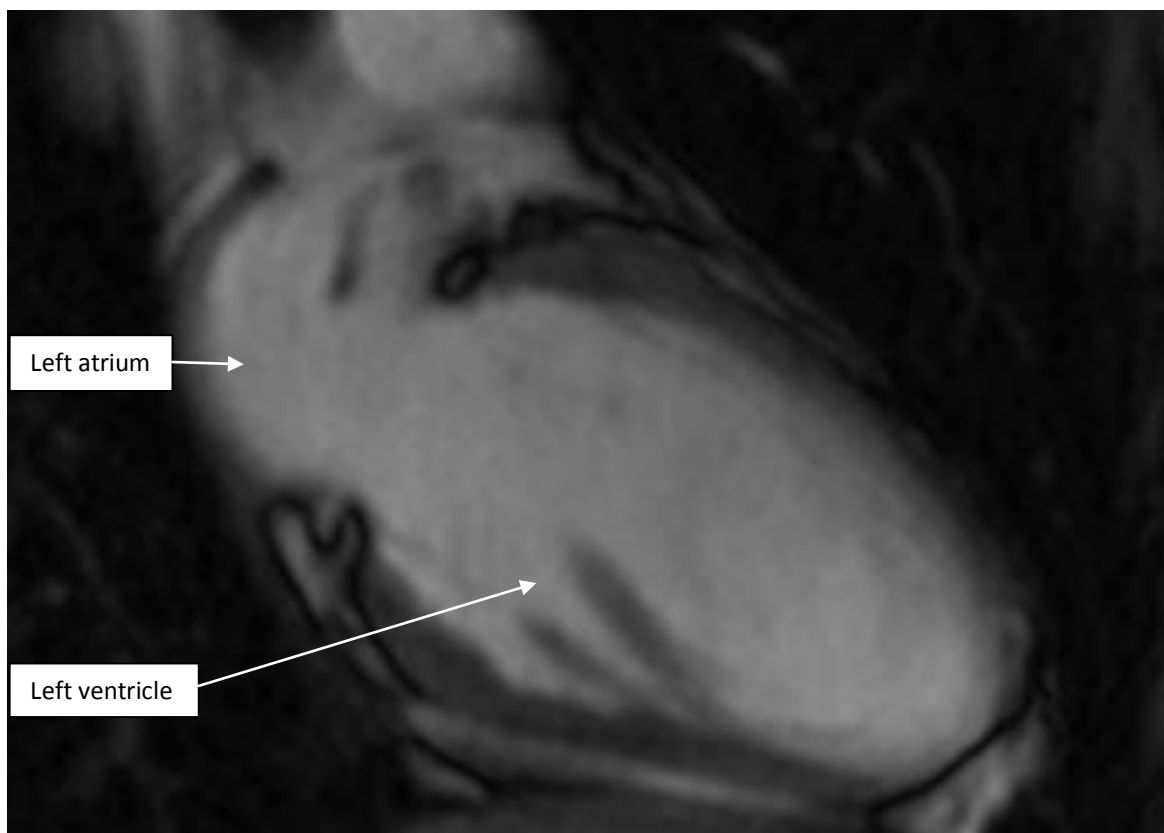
MRI CINE two chamber view (vertical long axis view) of left ventricle at diastole
